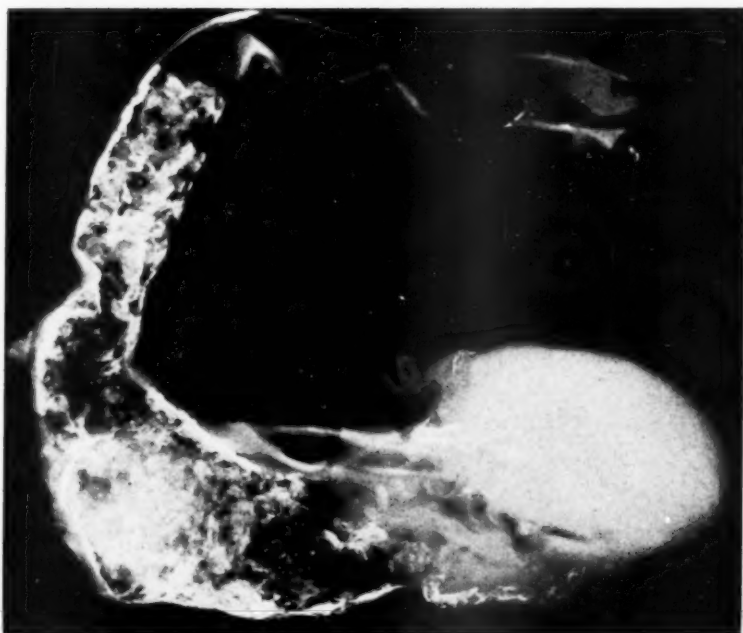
Post-mortem x-ray film of aorta shown in Fig. 1.
